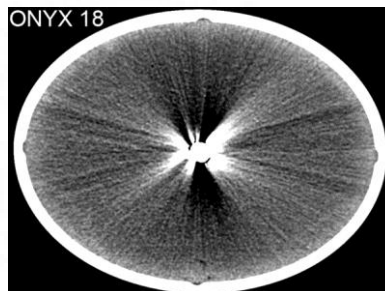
Artifacts in CT due to Onyx 18 (Pop et al., 2019).
